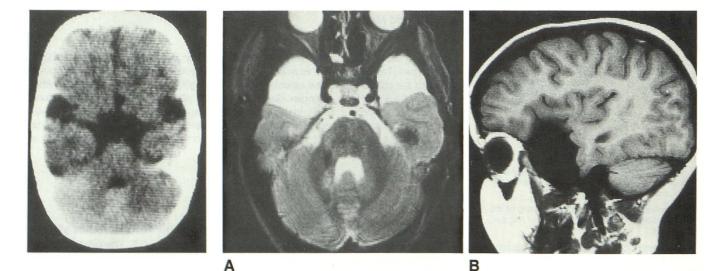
Case 1. Axial CT scan of 2-year-old boy shows fluid collections of the temporal regions, consistent with arachnoid cysts. Fig. 2.—Case 2. Five-year-old brother of patient in case 1. A and B. Axial (3100/90) (A) and sagittal (600/15) (B) MB
